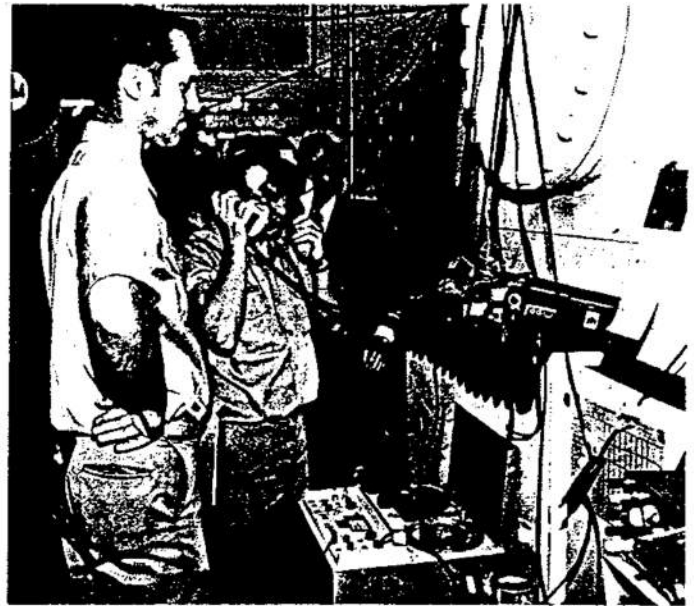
Topside Doppler monitoring, Nisat/He III.
